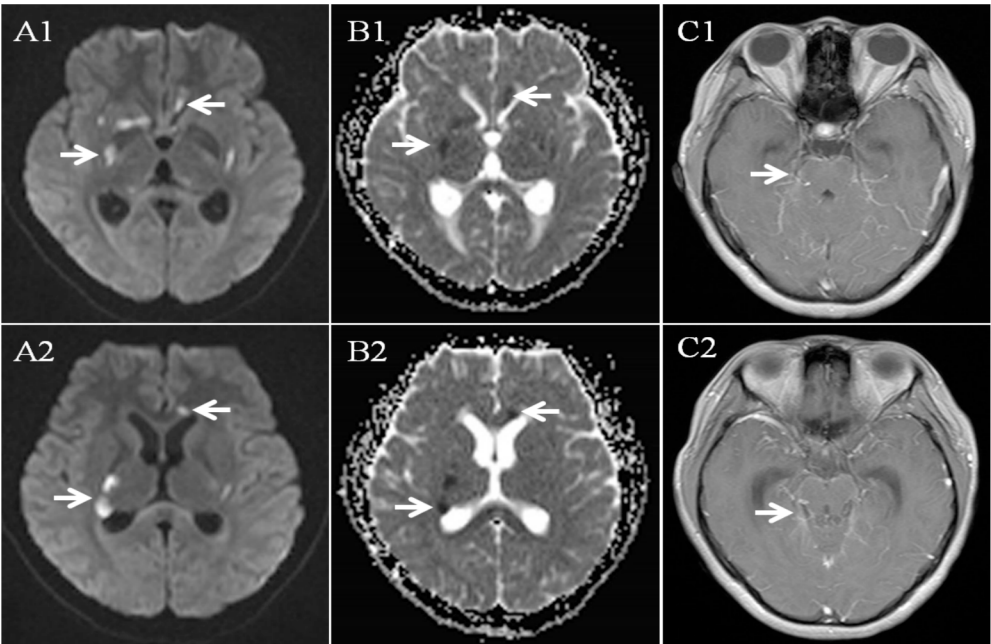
A 18-year-old female with TBM. (A1-A2) Axial diffusion-weighted imaging (DWI) and (B1-B2) apparent diffusion coefficient (ADC) showed multiple stroke lesions involving bilateral anterior circulation (arrow). (C1-C2) Axial enhanced magnetic resonance imaging (MRI) showed basal meningeal enhancement (arrow).
